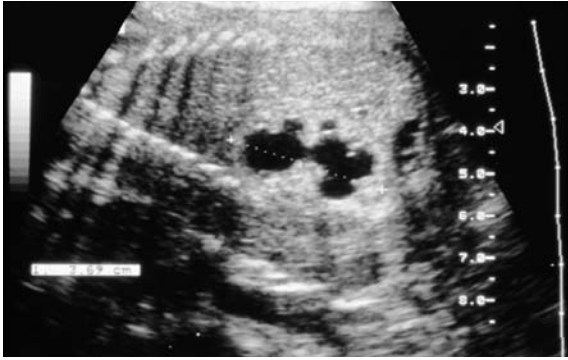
Prenatal ultrasound. Marked dilatation of a fetal kidney – PUJ obstruction confirmed by postnatal investigations.
